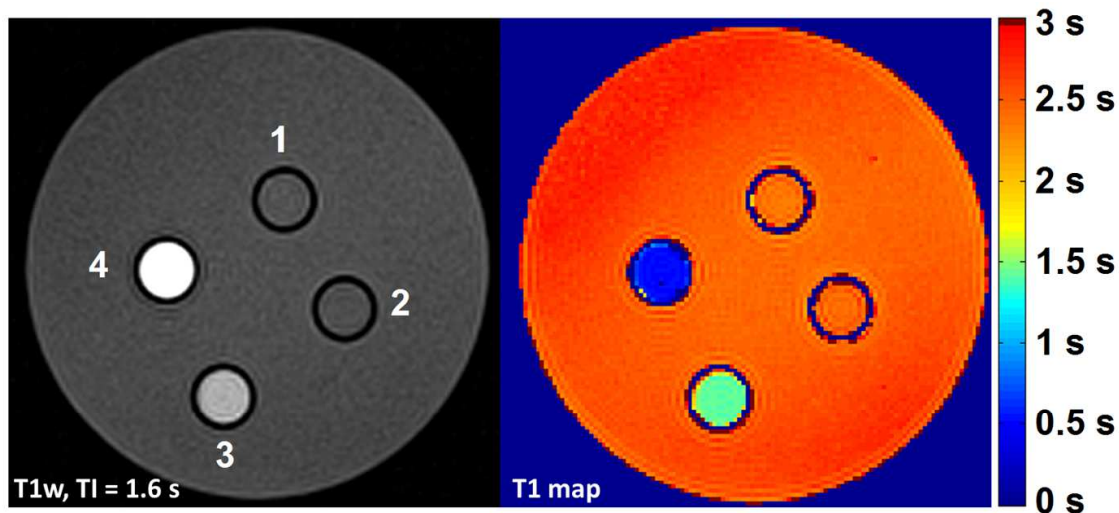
MR images of 1. 14 (2 mM in water), 2. Water, 3. Water + 20 % piperidine and 4. 14 (2 mM in water + 20 % piperidine).
